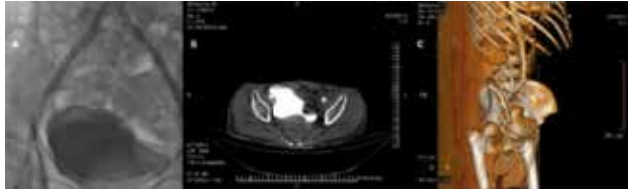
(A) Final angiogram displaying patent right iliac artery lumen and stents. (B) Computed tomography showing bulging of bladder on iliac stents. (C) 3D volume rendered image depicts right displacement of bladder on stents resulting femoral nerve compression.
